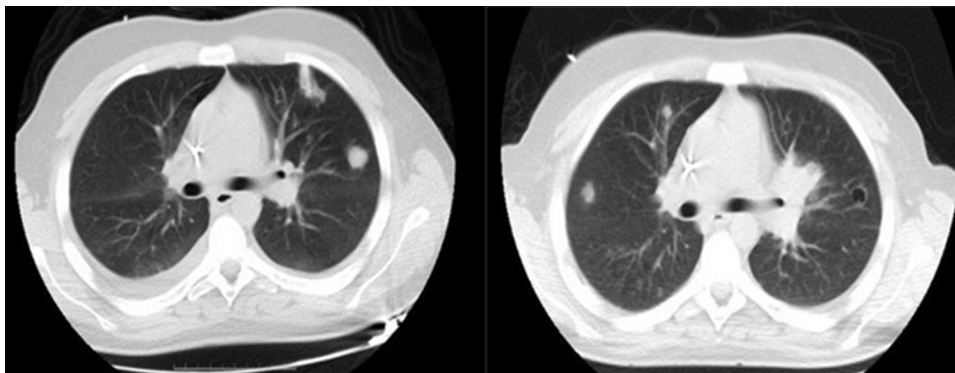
chest computed tomography (CT) scans showing multiple pulmonary speculate nodules (MPN) in upper right lobe, well-defined 10 mm cysts contain air (air cyst) and hilar opacified acinar nodule 48mm \times 46 mm diameter in the left upper lobe accompanying pleural effusion.
